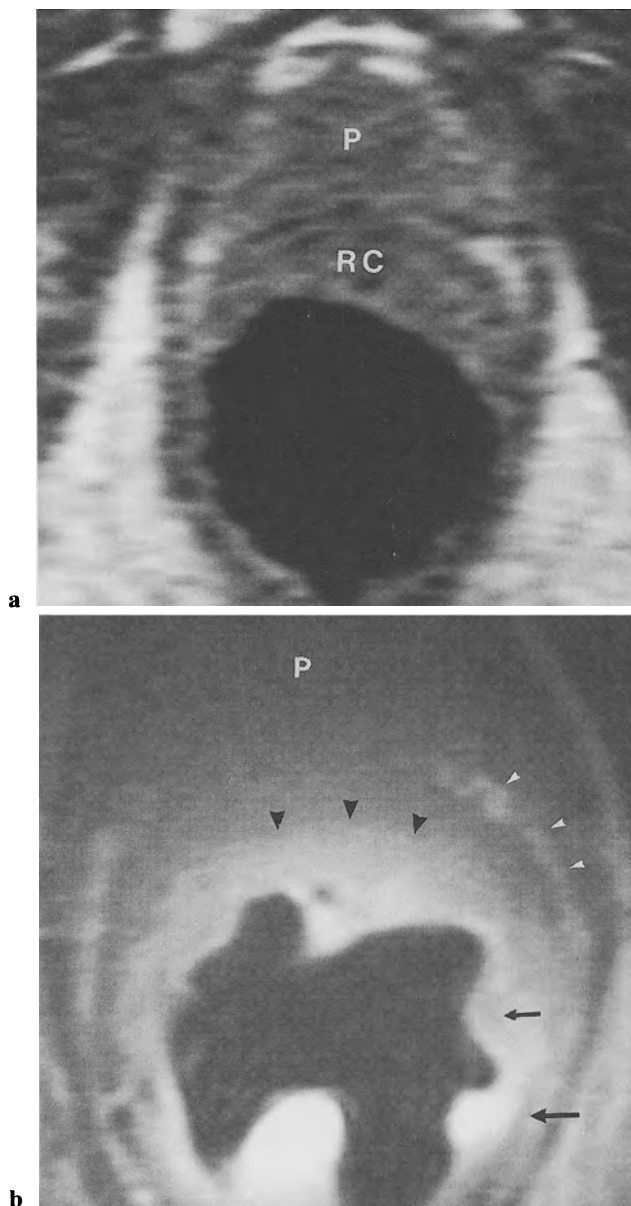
Rectal cancer stage T4. a Axial T2-weighted SE image (2500/22-90) with conventional MR imaging. *RC*, Rectal cancer; *P* prostate. b Axial T1-weighted SE image (700/15) with endorectal surface coil post contrast (0.1 mmol/kg body wt. Gd-DTPA) demonstrates rectal cancer with infiltration of submucosa, muscularis propria, perirectal fat, and prostate (indicating a stage-T4 lesion). Visualization of thickened mucosa (*black arrowheads*), as well as normal parts of submucosa (*short black arrow*), muscularis propria (*long black arrow*), perirectal fat (*white arrowheads*), and the prostate (*P*)
